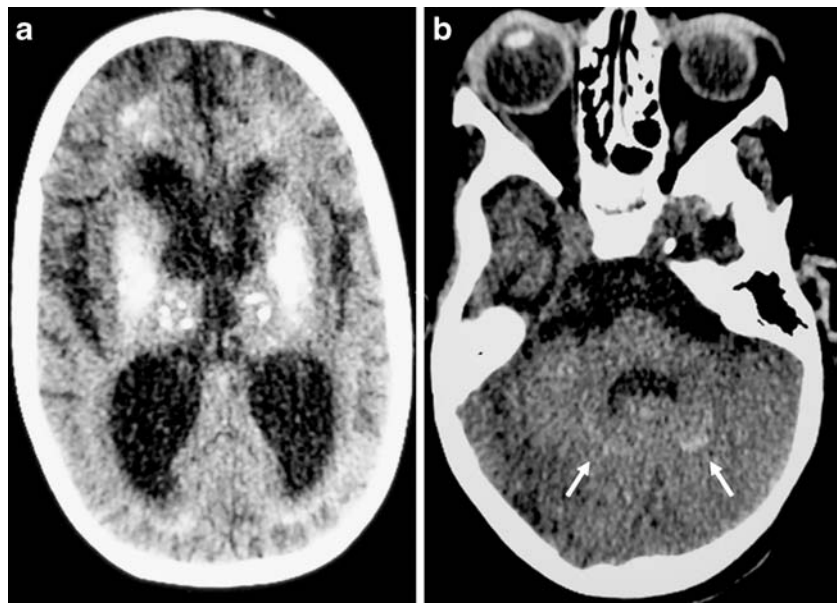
Non-contrast CT brain in a 3-year-old boy with Aicardi-Goutieres syndrome. a Calcification is seen in the basal ganglia, both thalami and the white matter of both frontal lobes and (b) in the dentate nuclei (*arrows*)
